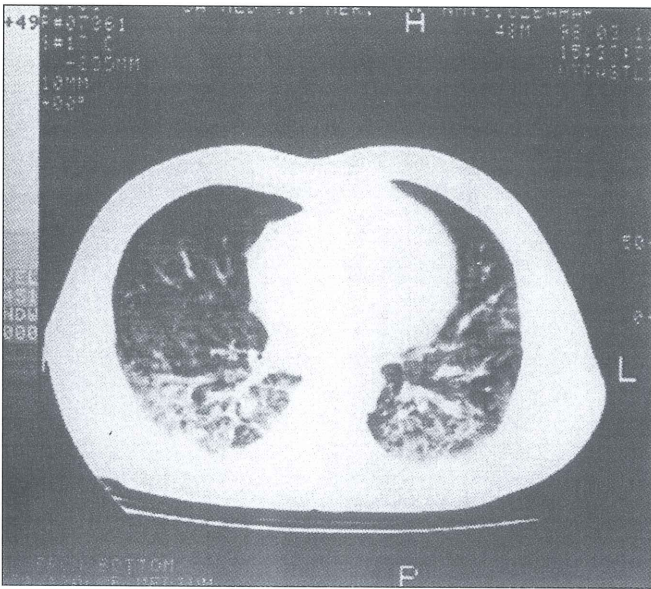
The computed tomography scan before therapy
